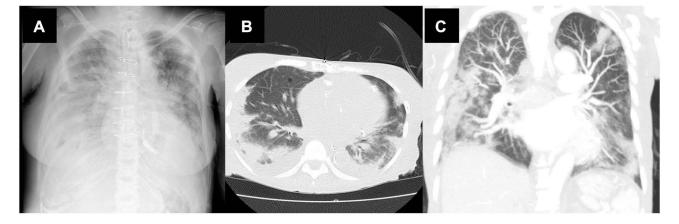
Radiographs and Computed Tomography of Lungs During COVID-19 Infection. Anteroposterior chest radiograph documenting pneumonia associated with SARS-CoV-2 infection (A). An axial CT scan revealed bilateral pleural effusions (B). A coronal CT scan revealed bilateral lung involvement and ground-glass opacities typically observed in patients diagnosed with COVID-19 (C).
